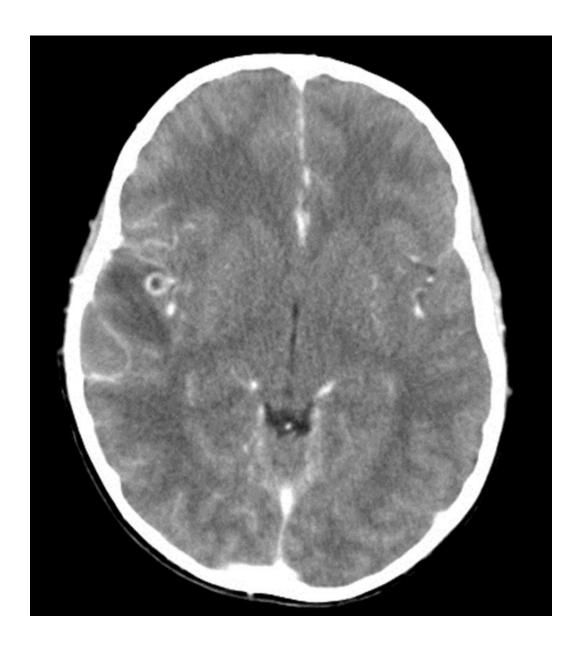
Contrast enhanced CT scan of the brain showing a cyst with a enhancing wall and an eccentric hyperattenuating scolex—Vesicular stage of NCC.
